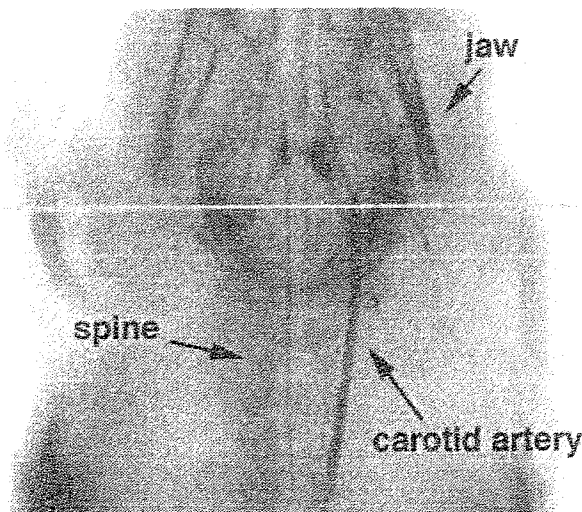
Radiograph showing the location of the subsequent reconstruction.
